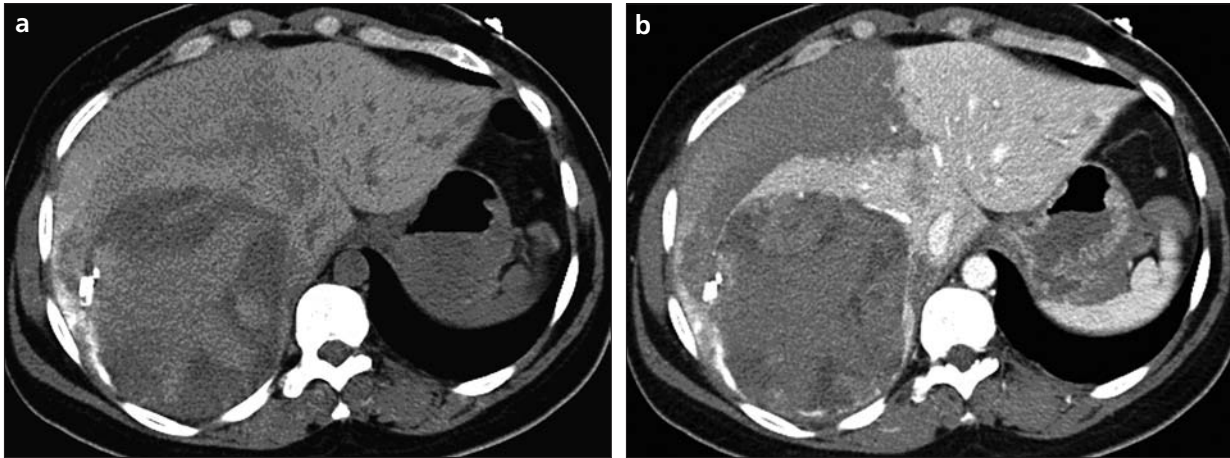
a, b. On control CT examination, precontrast (a) and postcontrast portal phase (b) images show that the sizes of intraparenchymal and perihepatic hematomas on the right lobe of the liver were increased owing to ongoing bleeding. However, there was no active bleeding. The glue materials and contrast material that were present in the perihepatic and intraparenchymal hematomas are seen clearly on the precontrast image (a). The enhancing parts of the tumor were visualized in anterior and posterior part of the lesion in the portal phase (b).
